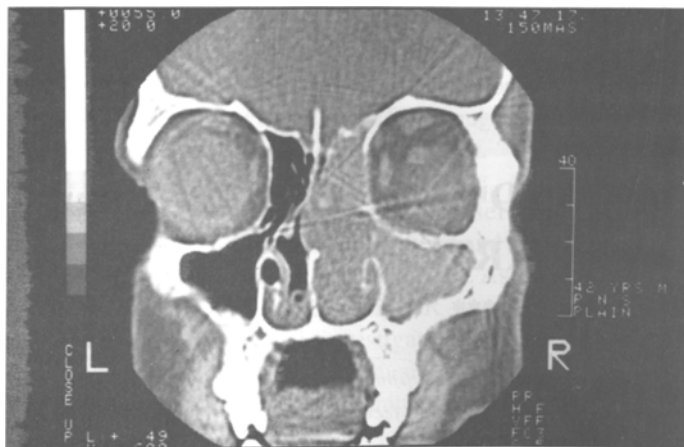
Coronal CT scan Head with contrast showing a slightly heterogenous mass filling the right maxillary antrum, nasal cavity and ethmoids without destroying the sinus septae.
